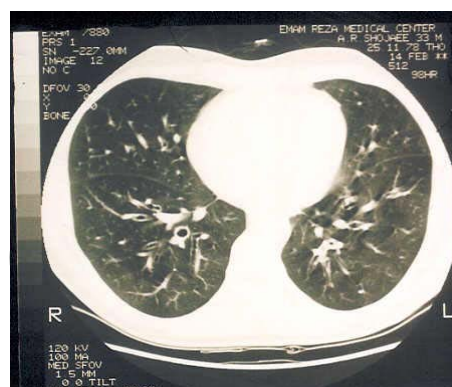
Computed tomographic scans showing Bronchiectatic lesions in the both Lungs
